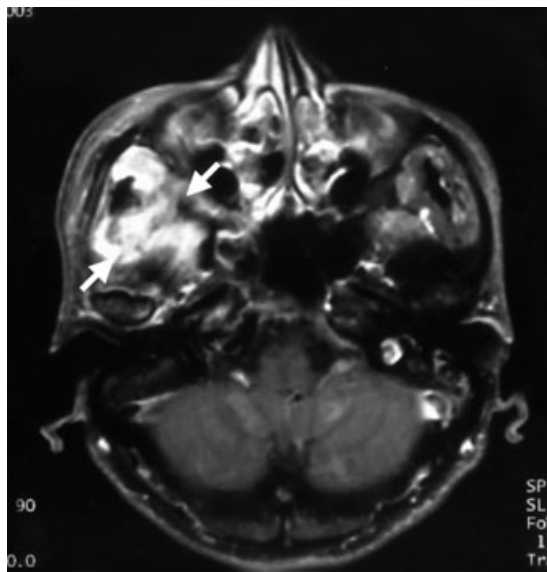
T1-weighted MR images enhanced with Gd-DTPA in December 2003. Horizontal plane (left) and the coronal plane (right). The arrows indicate areas in the infratemporal fossa and the adjacent meninges of that are enhanced.
